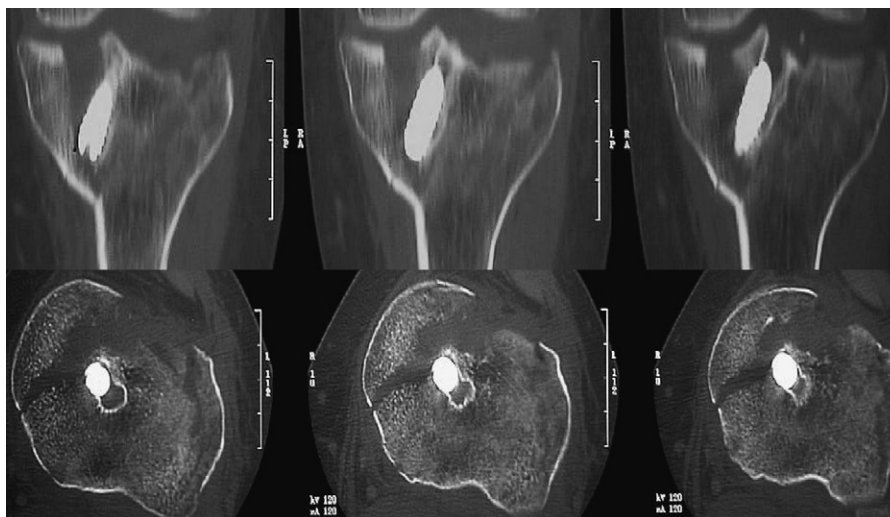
Coronal and horizontal CT scan images demonstrating the complex bi-condylar fracture in of the tibial plateau—the medial component clearly passes through the interference screw tunnel.
